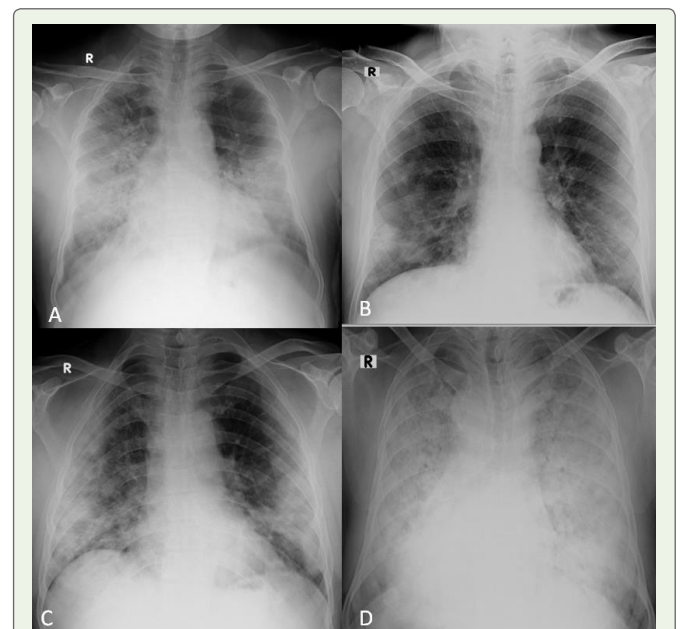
Radiographic patterns in SARS-CoV 2 pneumonia. (A) Alveolar opacities in bilateral mid-zones and right upper zone. (B) Consolidation with alveolar opacities in bilateral lower zones. (C) Patchy consolidation in bilateral lower and mid-zones. (D) Diffuse radio-opacities in bilateral lung fields with dextrocardia.
